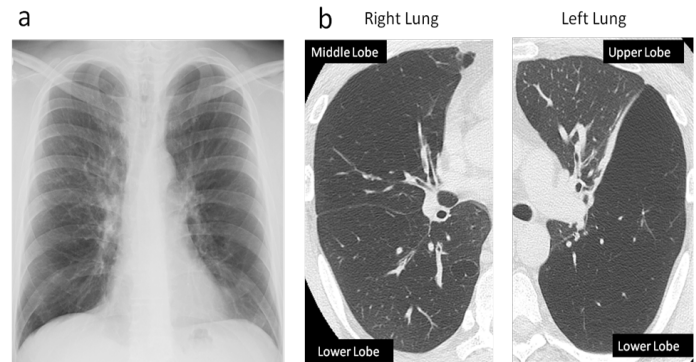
(1a) Chest X-ray showed hyperinflation in the right lower lobe and left lung.
